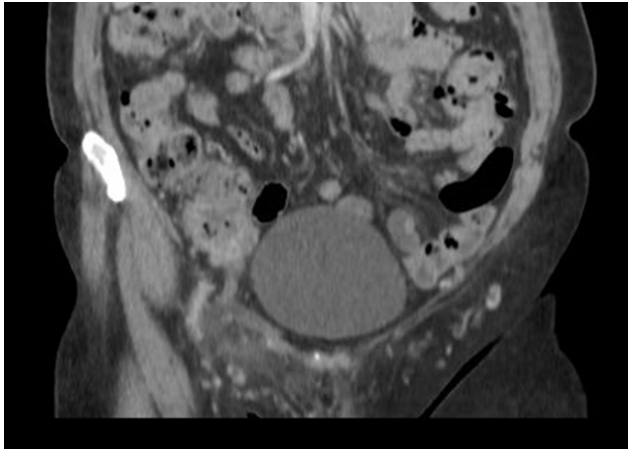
CT scan of the abdomen/pelvis revealing appendix entering groin
